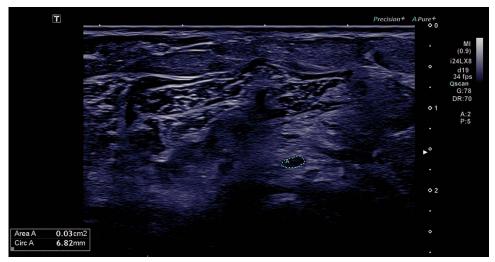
Neurosonographic evaluation of the deep branch of the radial nerve (A) at the arcade of Frohse before nerve decompression. The nerve's cross-sectional area (blue circle) is significantly enlarged to 0.03 cm² in contrast to a reference value of about 0.01 cm² in healthy individuals.
